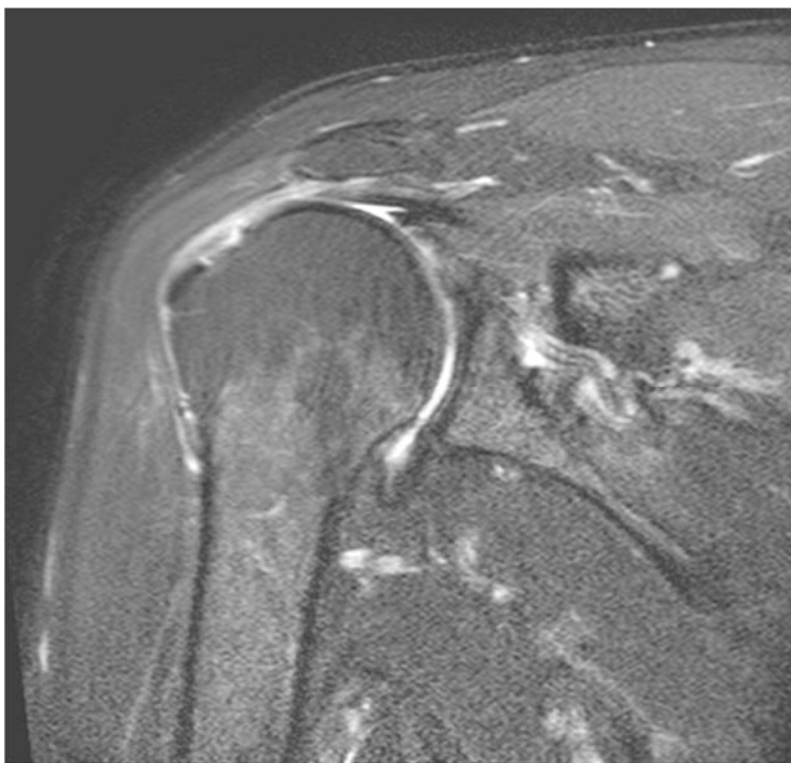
Suboptimal but still readable coronal intermediate-weighted fat-suppressed MRI of the shoulder with motion artifact (zebra artifact). Please repeat sequence if possible.
